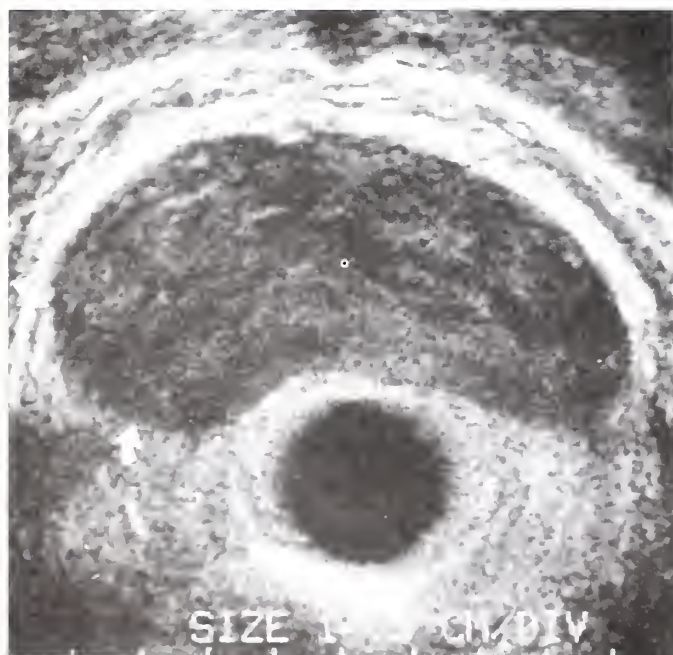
Stage B2 prostate carcinoma. Transrectal ultrasound. Gland is enlarged, but the echogenicity throughout the peripheral zone is homogeneous. At surgery, a B2 lesion was present in the right side (arrow) of the gland.
